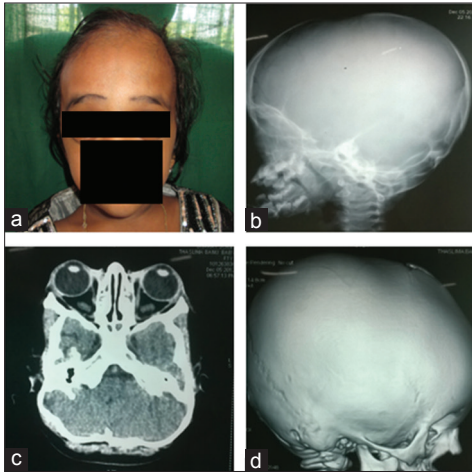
(a-d) Extraoral, lateral skull radiograph, and computed tomography scan of the patient
